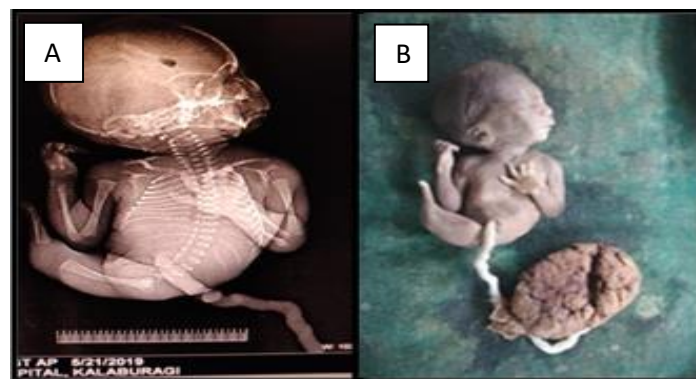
Sirenomelia (A) X-ray shows hypoplastic lower limbs (B) Fused limbs and absent external genitalia.
